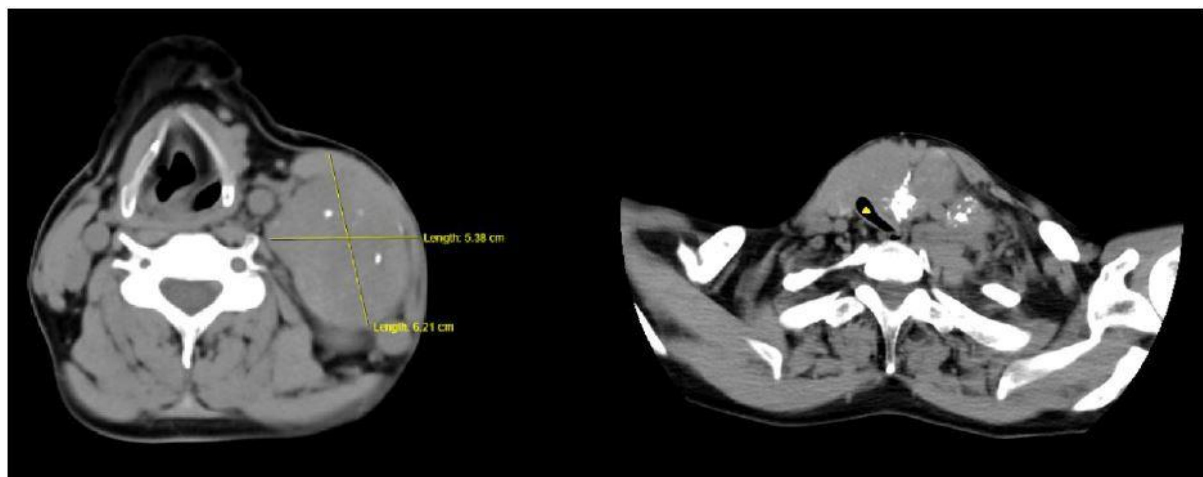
Computed tomography image of the patient. Giant thyroid tumor with significant right-sided tracheal compression (yellow triangle).
